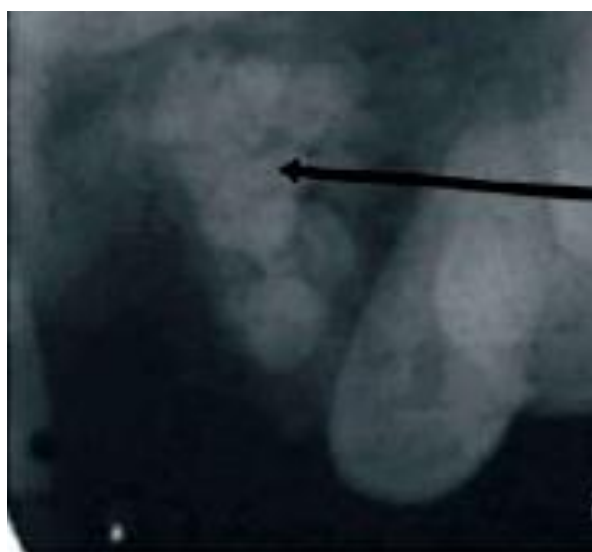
Radiographic image shows irregular radioopaque mass with radiolucency.
